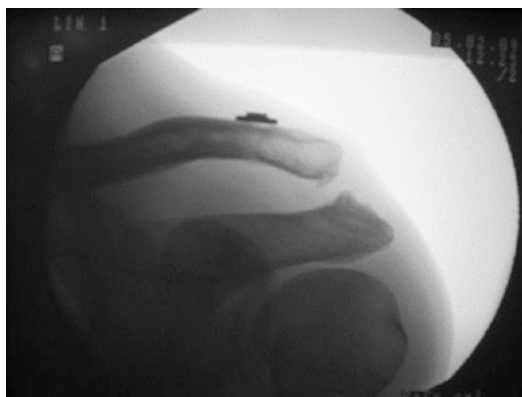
Left shoulder, X-ray showed a recurrence of the dislocation
